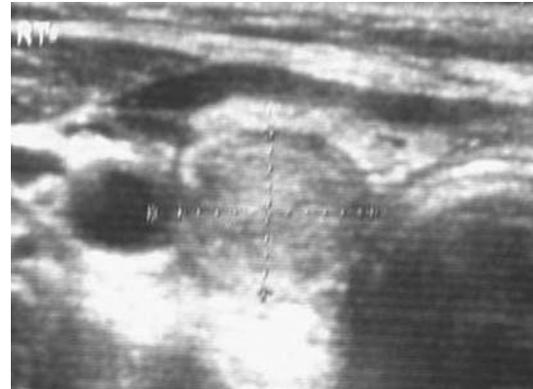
Sonography of the neck. Parathyroid Adenoma.
